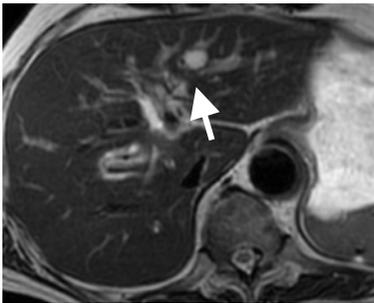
Hepatic hemangioma (left: T2-WI, right: DWI; black and white inversion)
